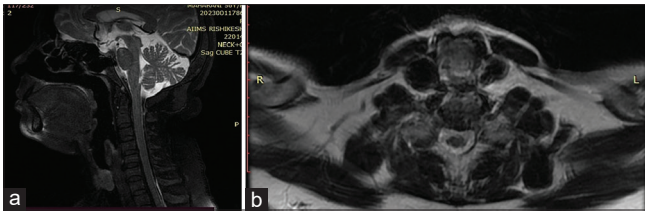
CE-MRI neck showing growth in the trachea at the C5–C6 level with near-total occluding tracheal lumen. (a) Sagittal section of contrast MRI showing growth in the lower end of the trachea. (b) Axial section of contrast MRI showing growth at the level of C5–C6 vertebra, causing near-complete occlusion of the tracheal lumen. CE-MRI = contrast-enhanced magnetic resonance imaging, MRI = magnetic resonance imaging
